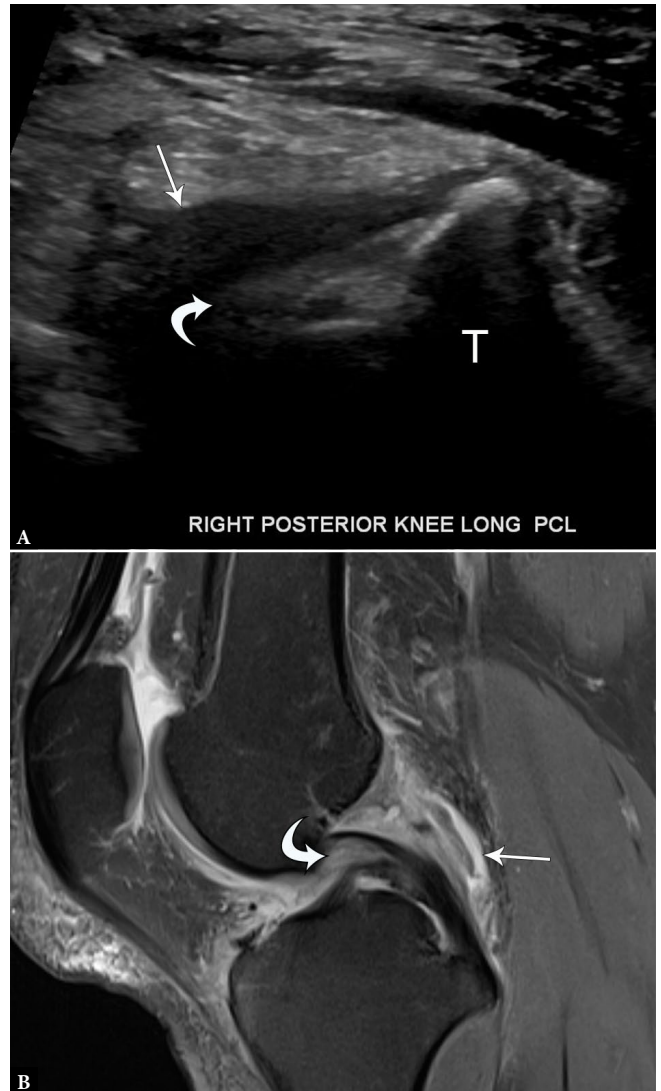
33-year-old male with partial posterior cruciate ligament tear. A. Longitudinal grayscale US image of the PCL demonstrates normal tibial attachment but indistinct, hypochoic proximal fibers (curved arrow) with surrounding hypochoic material (arrow). B. Sagittal proton-density-weighted fat-suppressed MR image shows edema and thickening of the proximal PCL (curved arrow) with surrounding edema and fluid (arrow)
